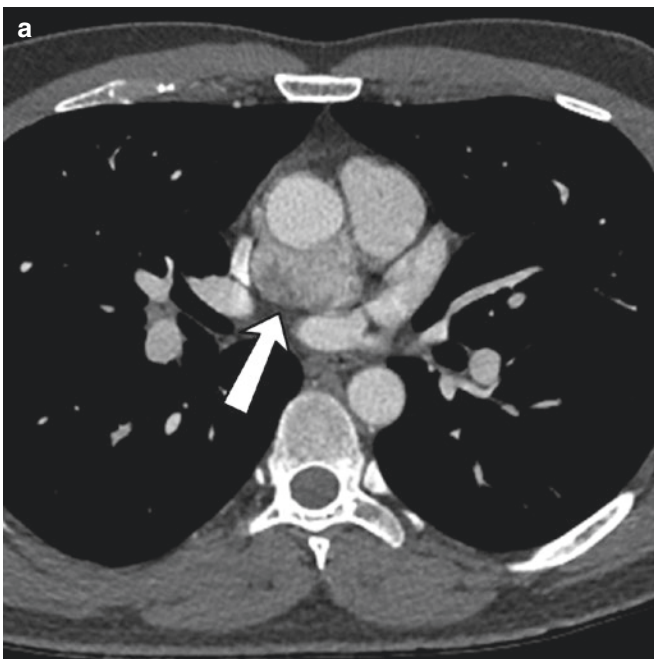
Hemangioma. Axial CT scan shows an intensely enhancing mass in between the right and left atrium (arrow), which was proven to be a hemangioma
